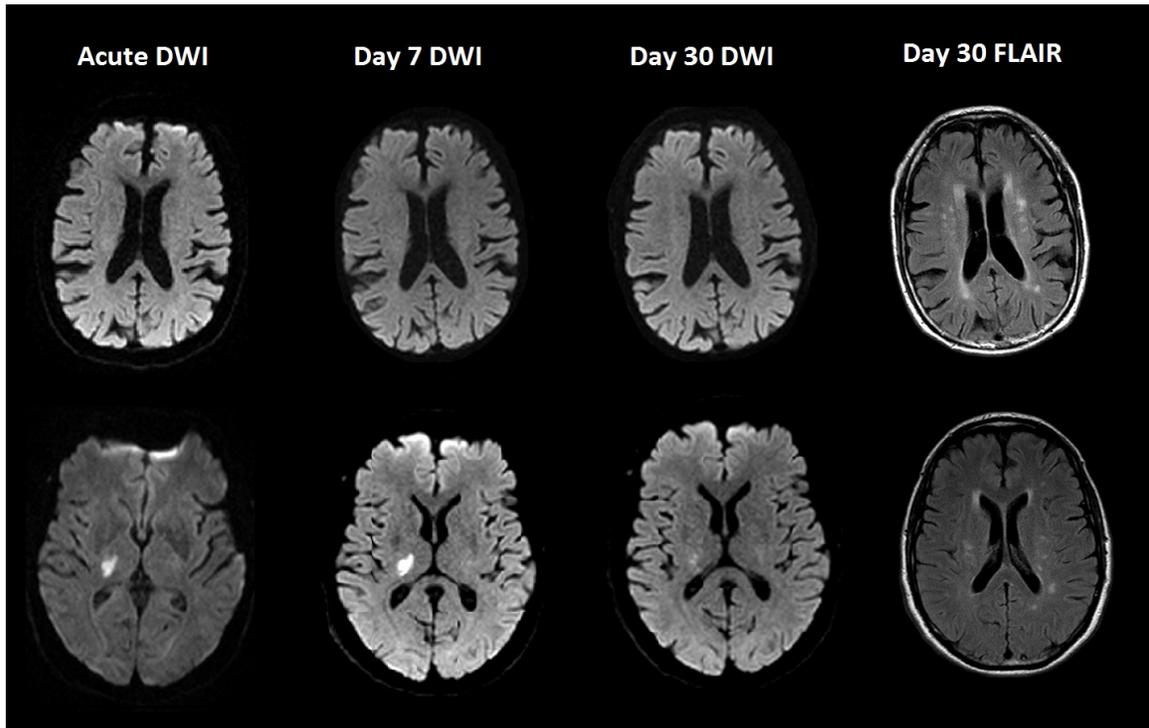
DWI and FLAIR MRI scans in two TIA/minor stroke patients over 30 days following symptom onset. Patient 1 (top row): negative DWI, impaired baseline MoCA (24); Patient 2 (bottom row) positive DWI, unimpaired at baseline MoCA (27). Both patients show evidence of leukoaraiosis on day 30 FLAIR sequences.
